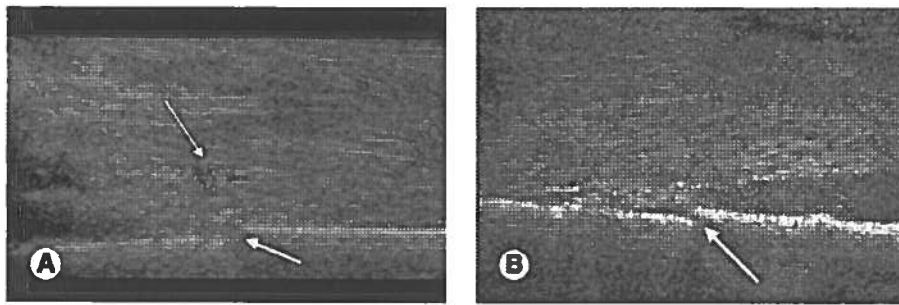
A) Replant patient. Color Doppler ultrasound performed at week 3 with vessels close osteotomy site. Short arrow, osteotomy site; arrow, vessels. (B) Replant patient. Ultrasound B mode at week 3. Arrows, osteotomy site, soft callus.
